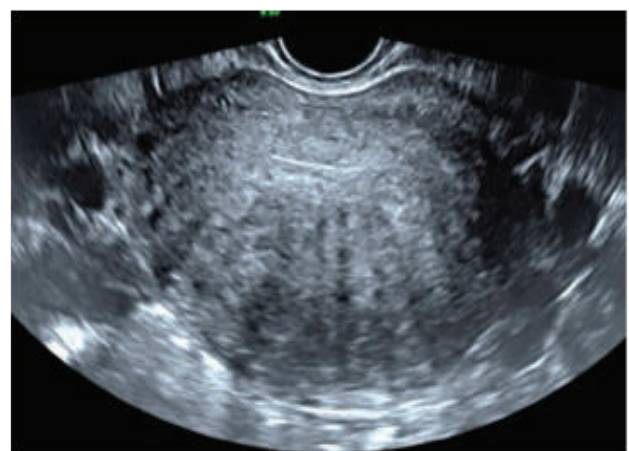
Adenomyotic changes in ultrasonography
